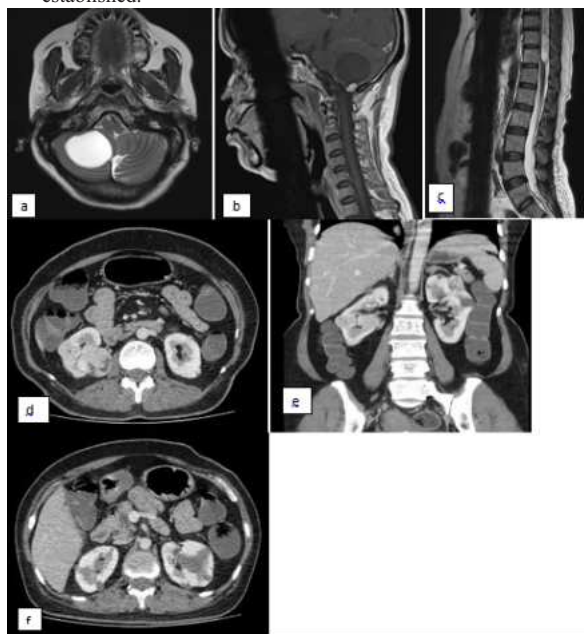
Axial T2W plain MR image of brain (a) showing a well defined hyperintense cystic lesion in the right cerebellar hemisphere causing mass effects on brain stem and 4th ventricle. Axial T1 sagittal post contrast images (b) showing enhancing solid mural nodule of the lesion- s/o
